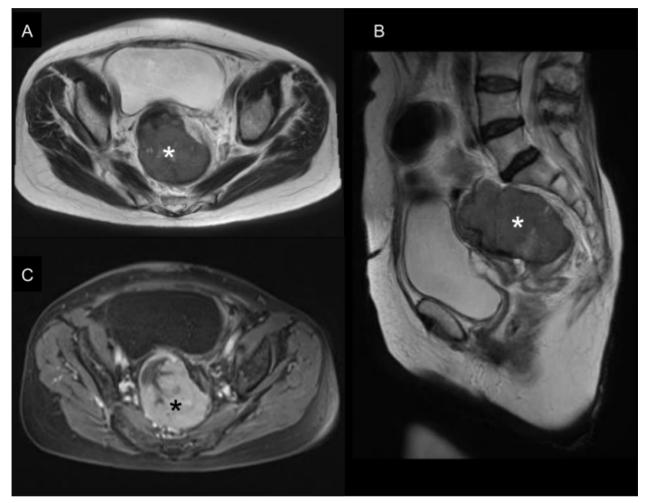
Pelvic MRI. A: Axial; B: Sagittal T2-weighted planes showing the lesion (*) with predominantly intermediate signal intensity with a halo of hypointensity; C: Post-gadolinium imaging showing heterogeneous enhancement confirming the solid nature of the lesion.
